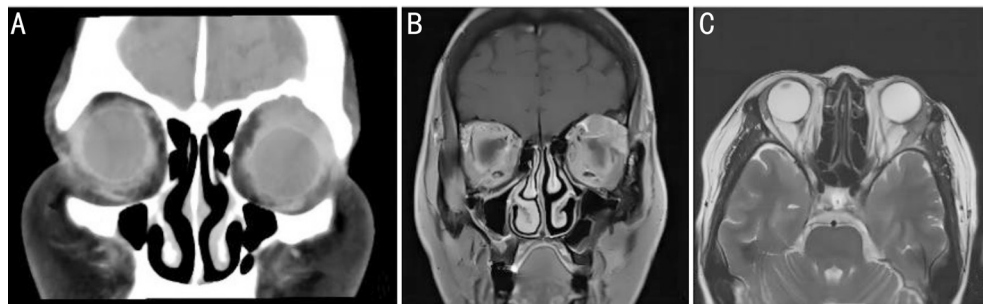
The CT scan images demonstrated that the orbital bony walls were continuous (A) and MRI scan images showed that the recurrent lesion was confined within the orbit (B, C).
